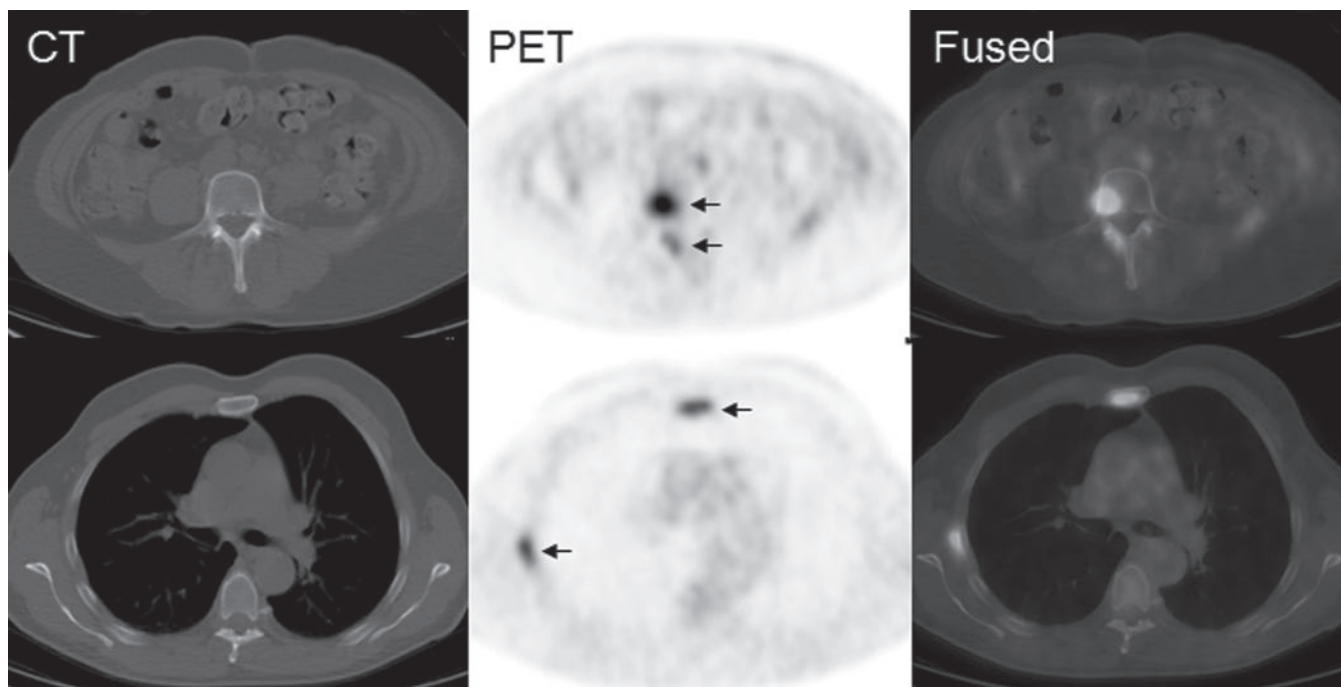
A 50-year-old man had bladder transitional cell carcinoma. This PET/CT image shows foci of intense fluorodeoxyglucose activity fusing a lumbar vertebra and pedicle, the sternum, and a right rib (*arrows*). Despite the lack of abnormality on the corresponding CT image, these findings are most consistent with osseous metastases.[†]
